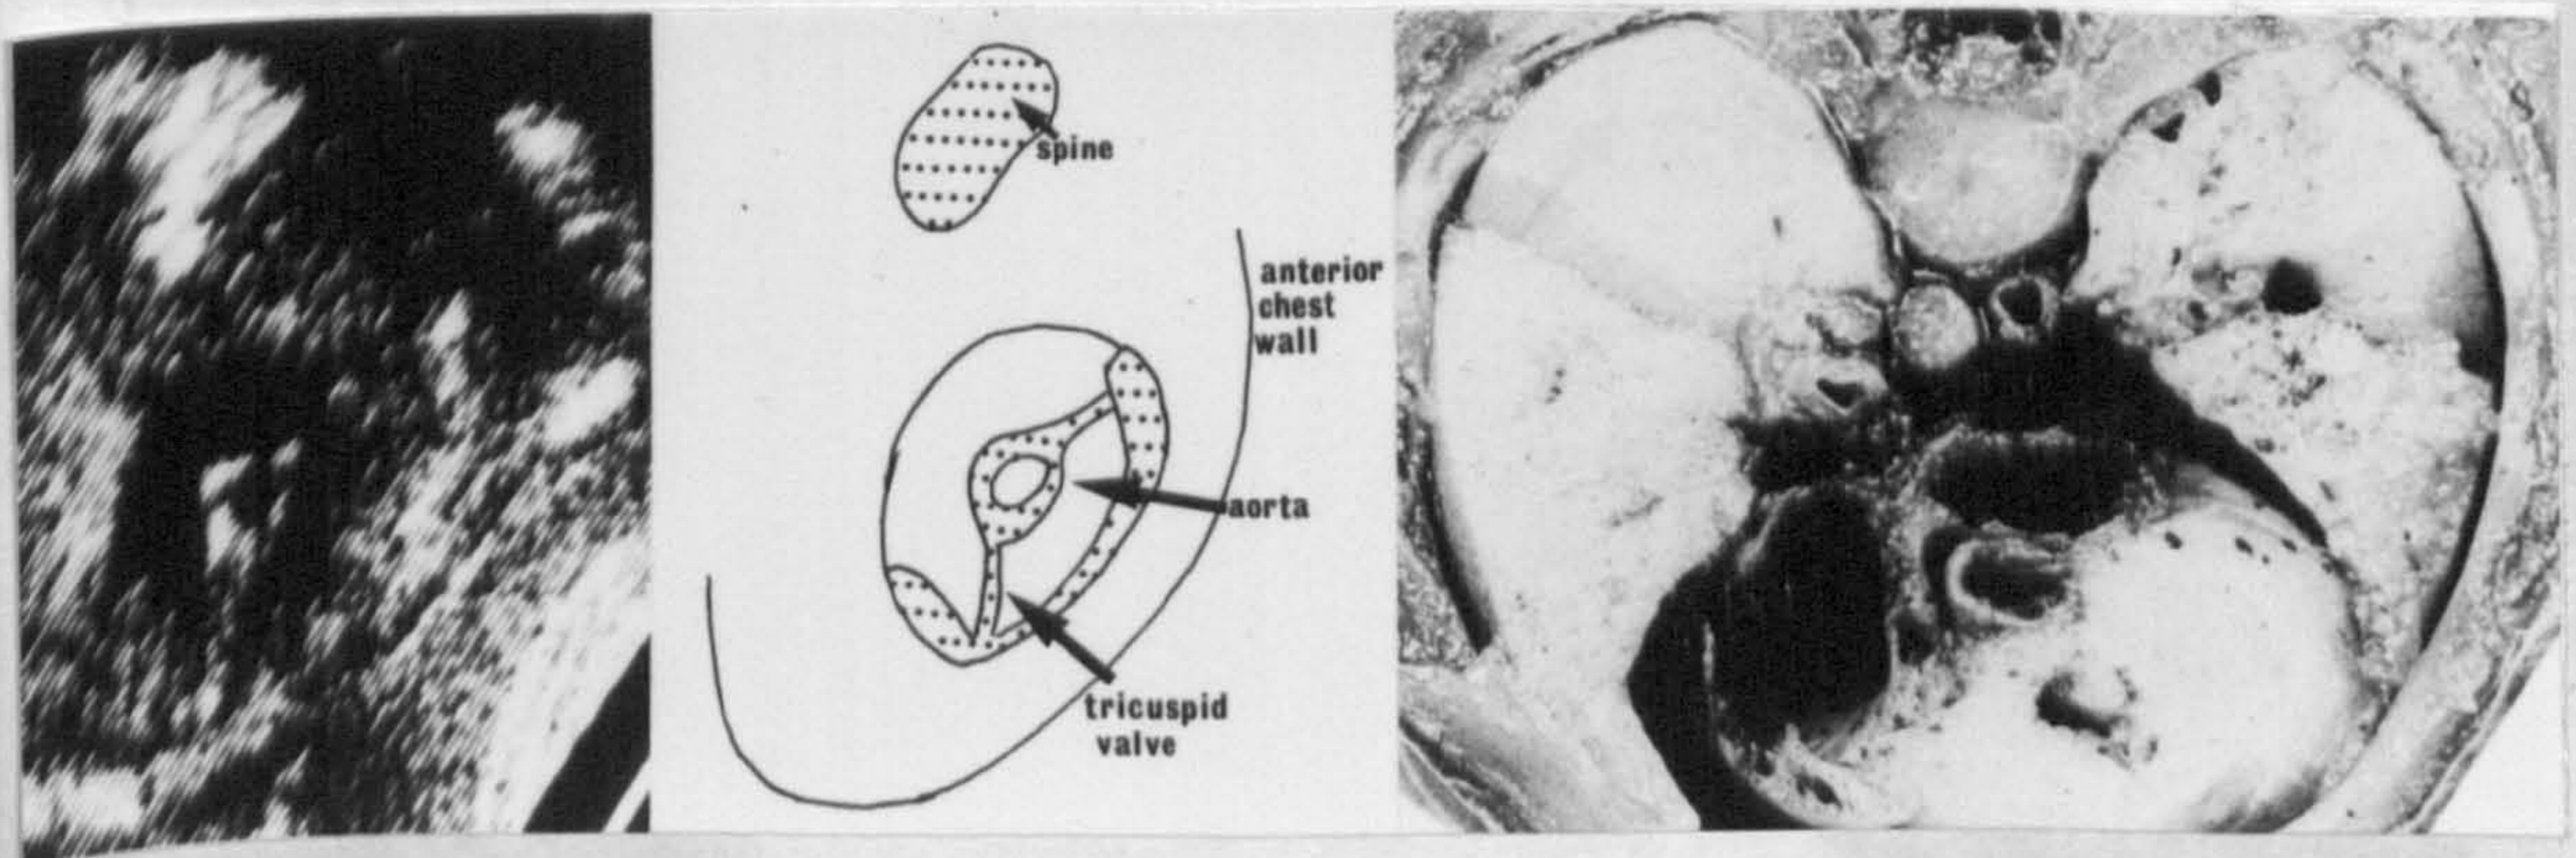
The aortic wedge plane is seen echocardiographically and anatomically. The aorta is wedged down between the two atrioventricular valves in the centre of the heart.
